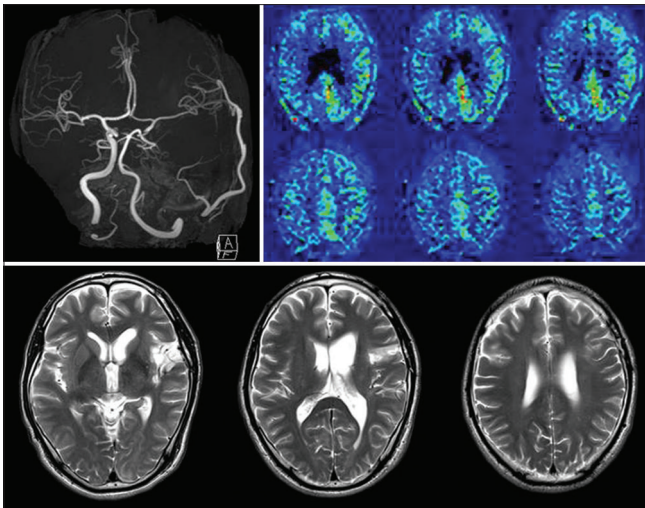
Magnetic resonance imaging studies at the 6th postoperative months. Intracranial magnetic resonance angiography (upper left) shows a robustly patent superficial temporal artery-middle cerebral artery bypass. Arterial spin labeling (upper right) demonstrates symmetrical cerebral blood flow in the bilateral middle cerebral artery area. T2-weighted imaging (lower) shows no additional ischemic lesion
